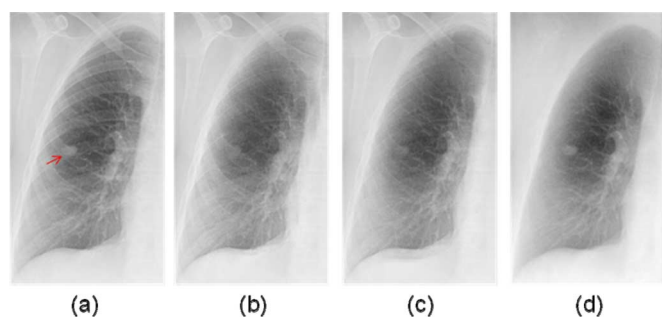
Result for an abnormal chest radiograph with a nodule that overlaps with both anterior and posterior ribs. (a) An original abnormal chest radiograph with a nodule (indicated by a red arrow), (b) a VDE soft-tissue image obtained by use of our original MTANN technique, (c) a VDE soft-tissue image obtained by use of our new MTANN technique, and (d) the corresponding “gold-standard” dual-energy soft-tissue image.
